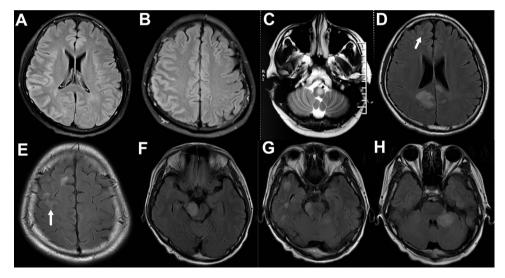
MRI presentations during different episodes. (A, B) MRI-Flair images showed the right temporal, parietal and occipital cortical lesion in the first episode; (C) Left medulla oblongata lesion on T2WI developed during the second episode; (D–H) MRI-Flair images during the fourth episode: (D) MRI-Flair images showed juxtacortical white matter lesion in frontal and occipital lobe; (E) Focal serpentine cortical lesion as well as juxtacortical white matter lesion in the right parietal lobe; (F–H) Lesions located at right mid brain, pons, left brachium pontis and temporal lobe.
